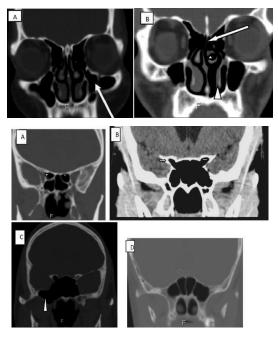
Coronal CT images from the study showing the different anatomical variants of the paranasal sinuses (A) multiple septations in the left maxillary sinus (arrow), (B) pneumatized left middle conchae (white star),(C) hypoplastic left inferior conchae (arrow head), deviated nasal septum (long arrow). Agger nasi cells (explosion), (D) sphenoid sinus extension into the anterior clinoid process bilaterally (arrows), (E) extension into the right pterygoid plate (arrow head) and (F) multiple sphenoid sinus septation.
